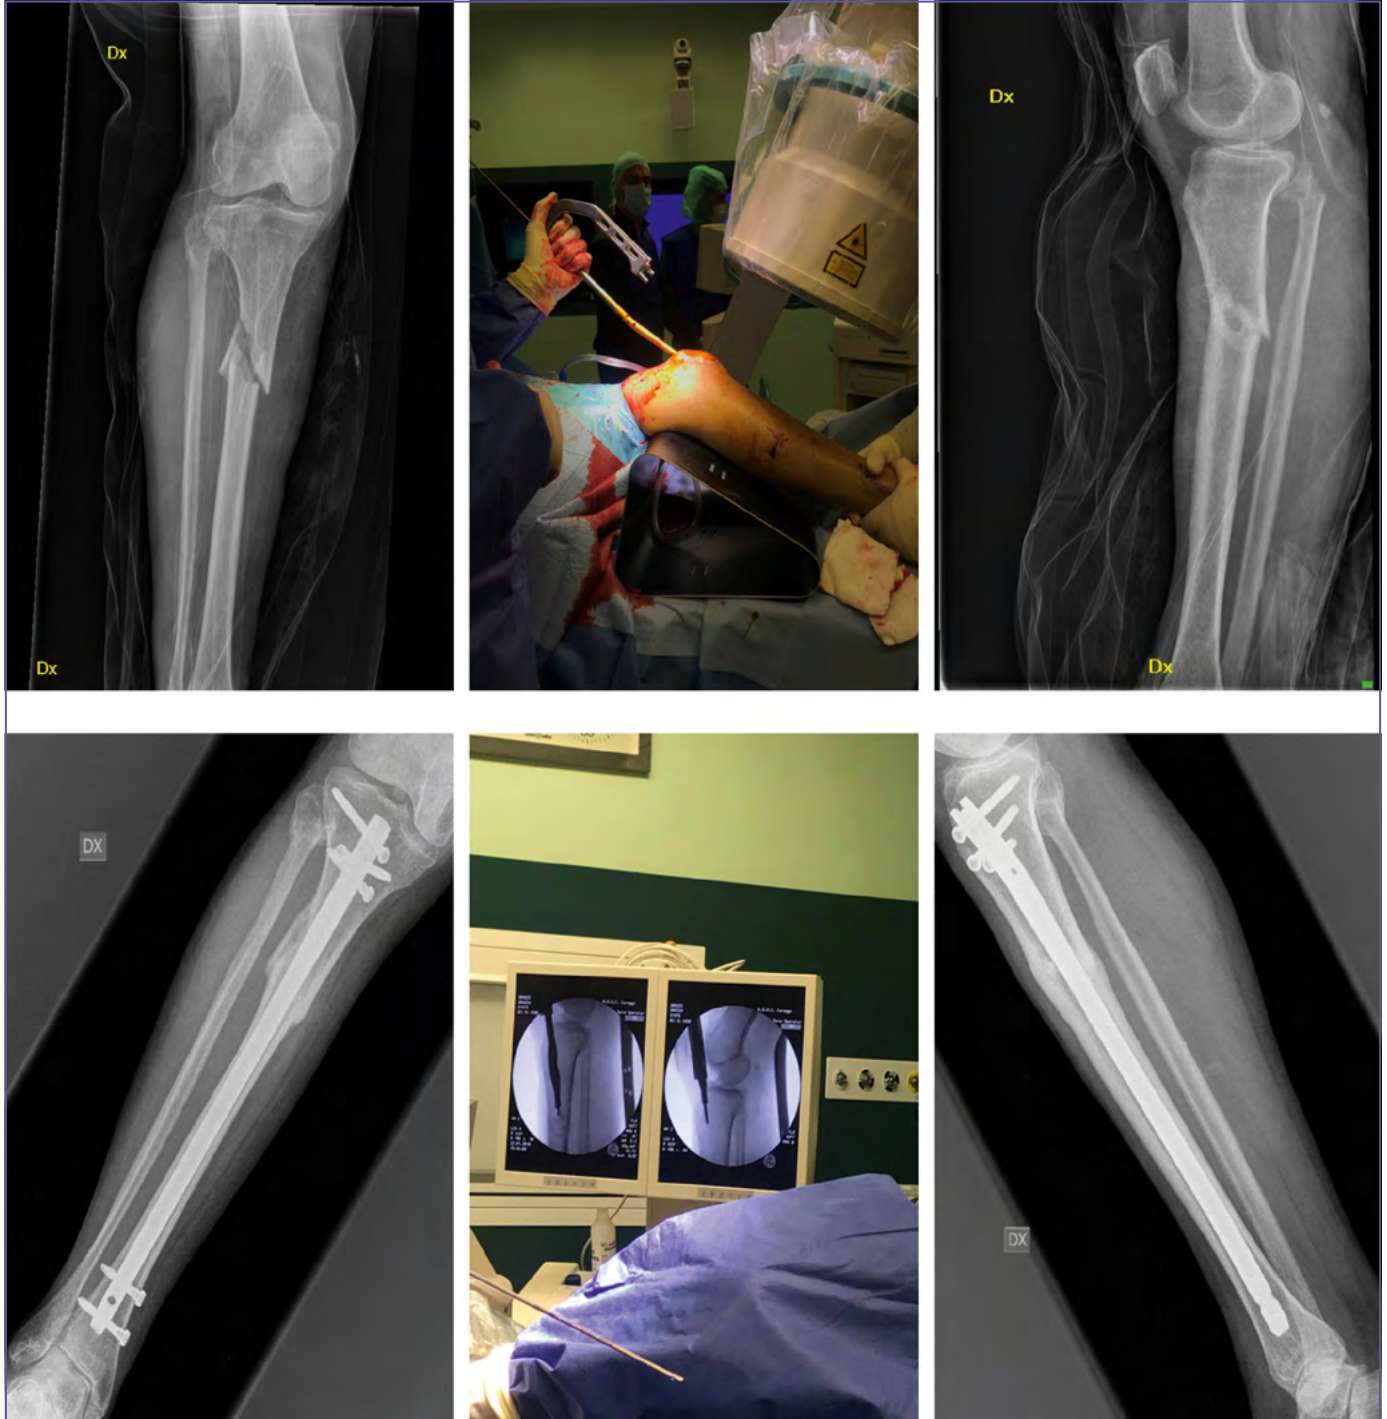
Intramedullary nailing with supra-patellar nailing (SPN) technique. A 79-year-old woman involved in a motor-vehicle injury, resulting in closed tibial shaft injury (AO 42B2, GA I). Pre-operative X-rays, intra-operative photos and post-operative X-rays at 32 weeks.
